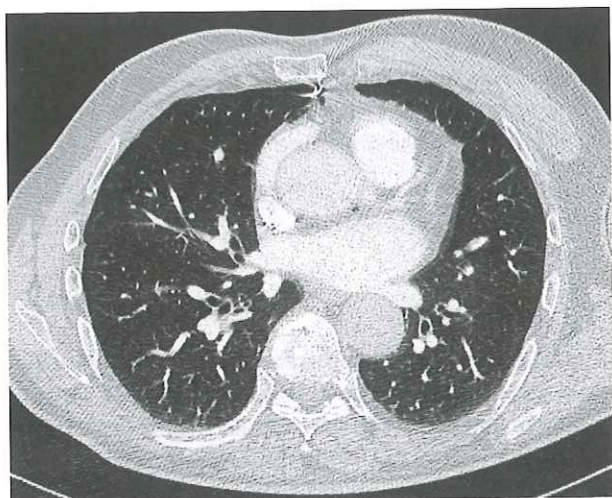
Thoracic computed tomography realized without intravenous contrast: the tip of the lead penetrates through the anterior mediastinum after perforation of the right atrium and the right lung.
